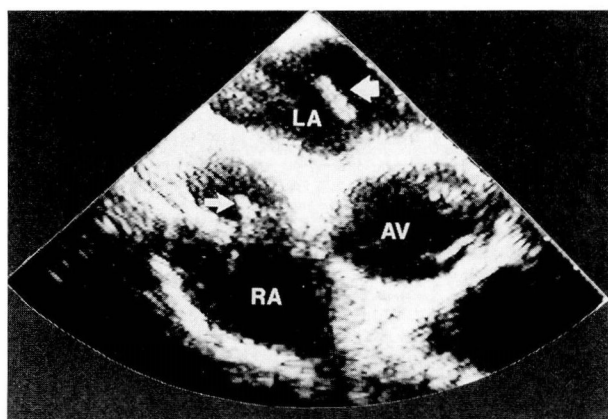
Two-dimensional transesophageal echocardiogram in a short-axis view (partially oblique) at the level of the aortic valve shows a metallic foreign body in the left atrium (large arrow). The small arrow points to a central venous catheter. AV, aortic valve; LA, left atrium; RA, right atrium.
